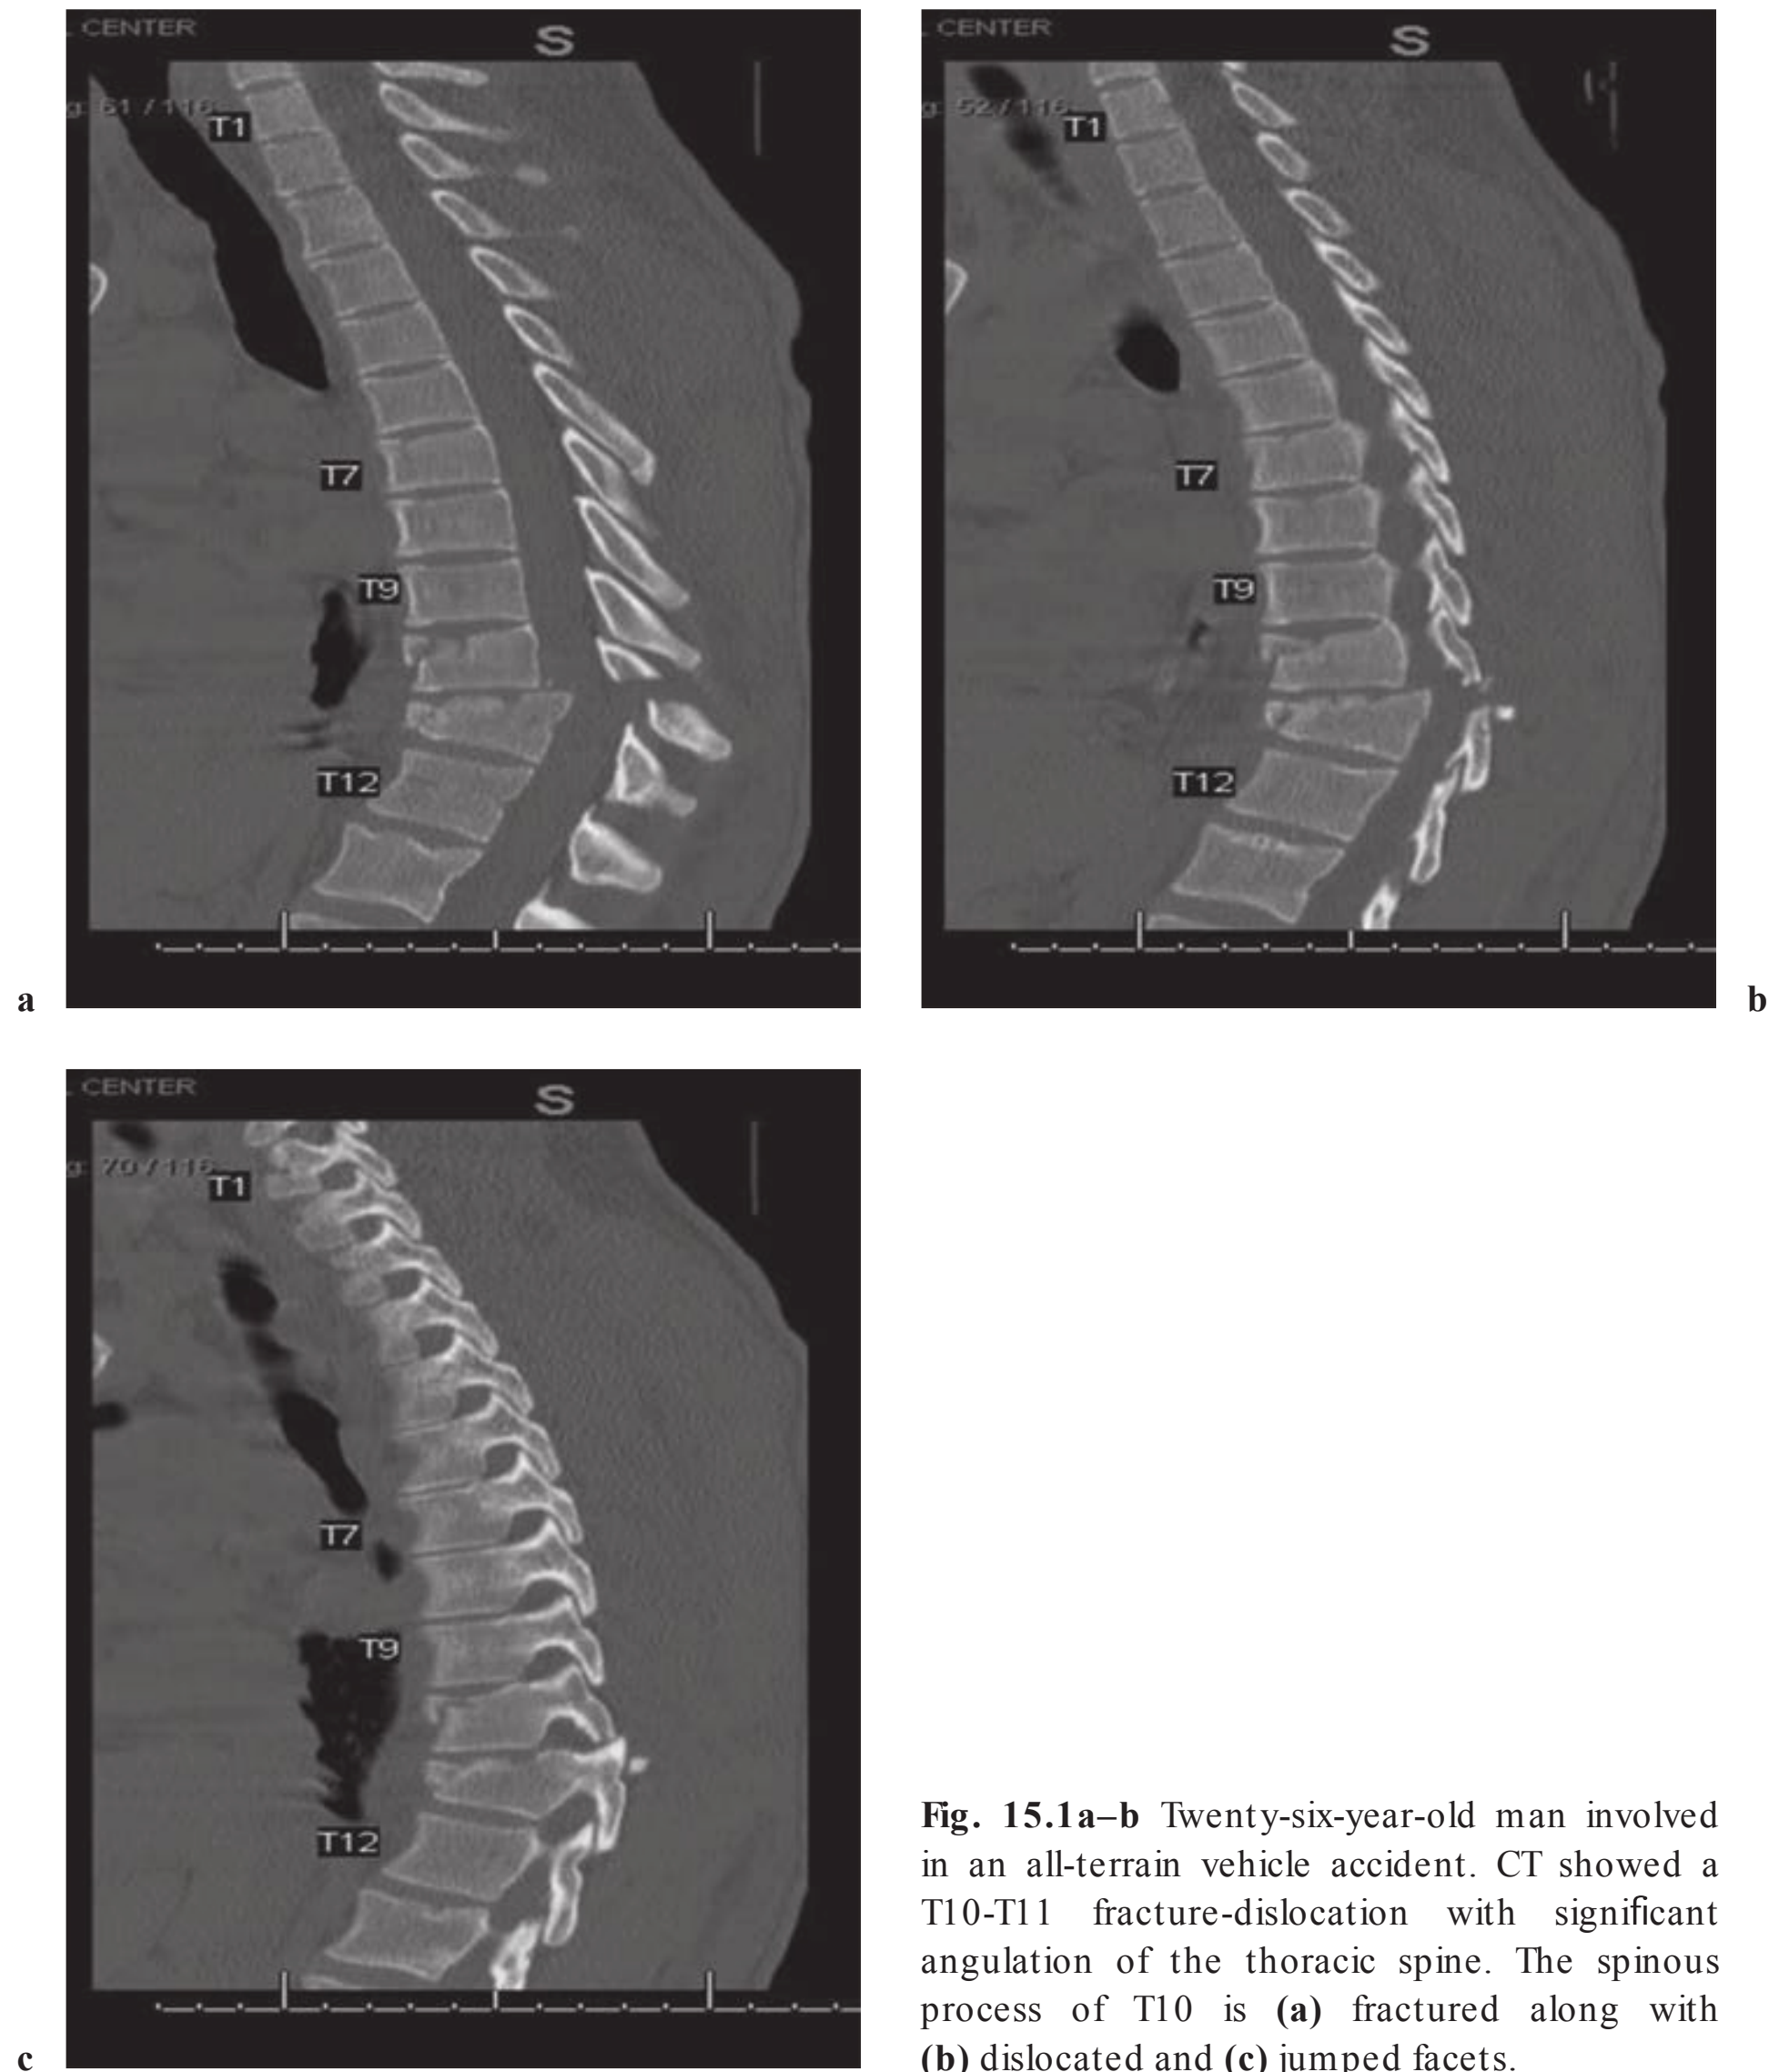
Twenty-six-year-old man involved in an all-terrain vehicle accident. CT showed a T10-T11 fracture-dislocation with significant angulation of the thoracic spine. The spinous process of T10 is (a) fractured along with (b) dislocated and (c) jumped facets.
